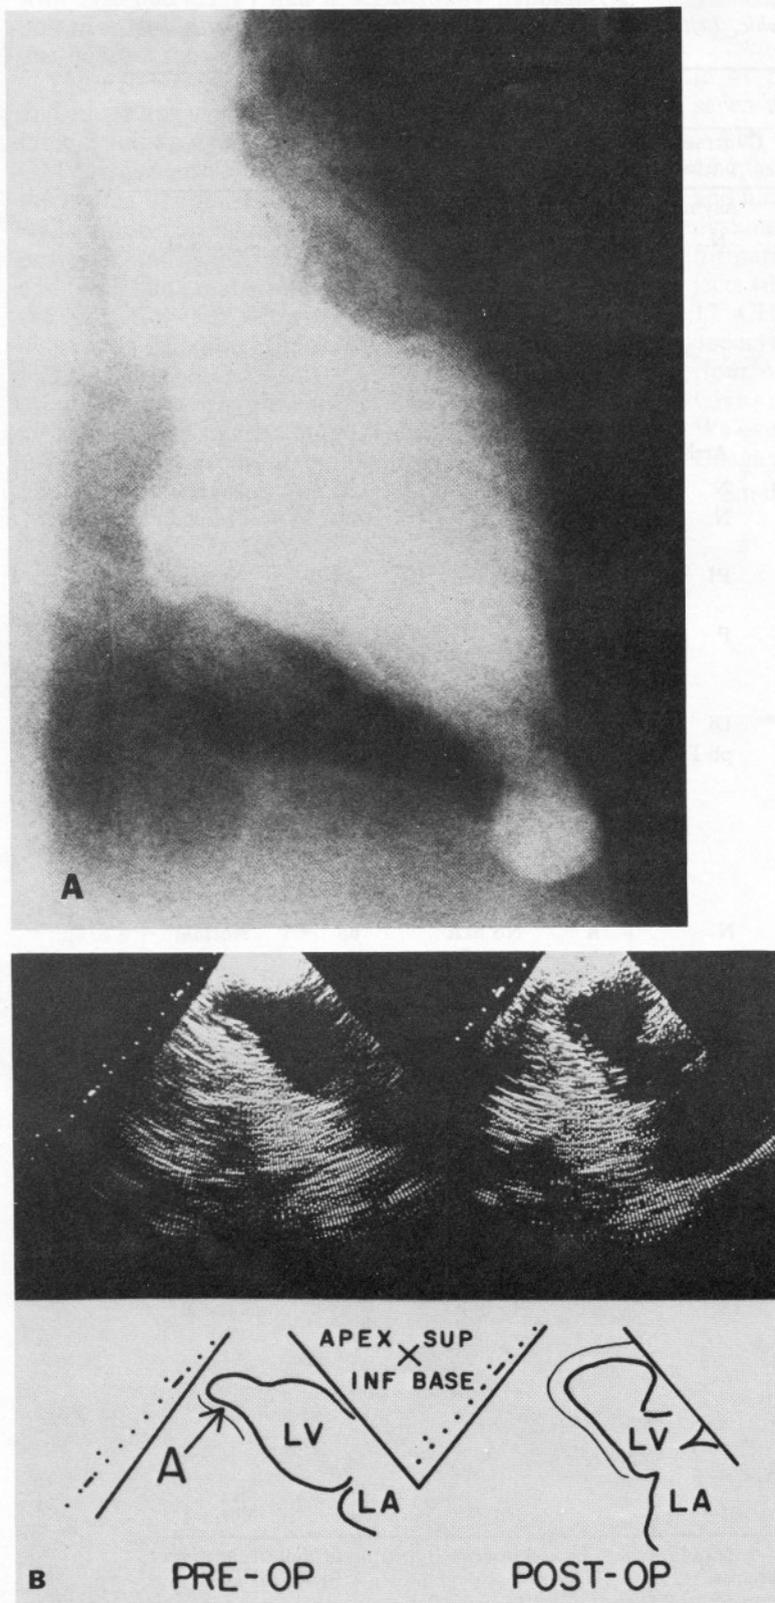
Angiographic and two-dimensional echocardiographic studies from a patient with a moderate-size apical aneurysm whose clinical course was complicated by frequent symptomatic episodes of ventricular tachycardia. (A) The right anterior oblique angiogram showing the apical aneurysm. (B) The echocardiographic, two-dimensional, apical two-chamber view of the aneurysm (A) as seen in systole (pre-op), and the same view after aneurysmectomy (post-op). LV = left ventricle; LA = left atrium.
